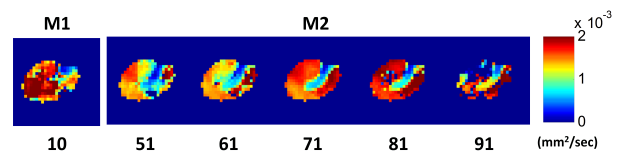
The right-kidney D maps acquired from one of the subjects. The number denoted beneath each D map indicates the number of b values selected into IVIM-model fitting. The acquisition times of DWI images were 6.8 min and 6.9 min for M1 and M2, respectively.
